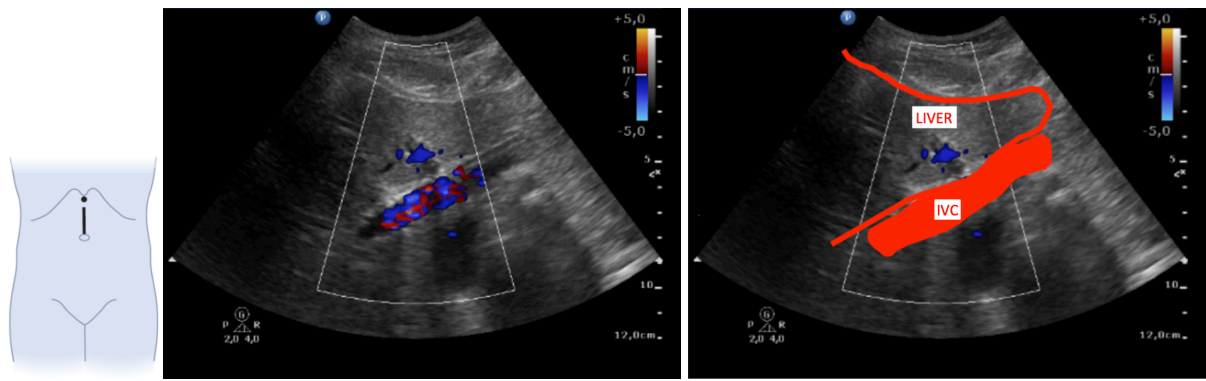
Vertical scan of the liver and the inferior vena cava (IVC) in Doppler mode.
